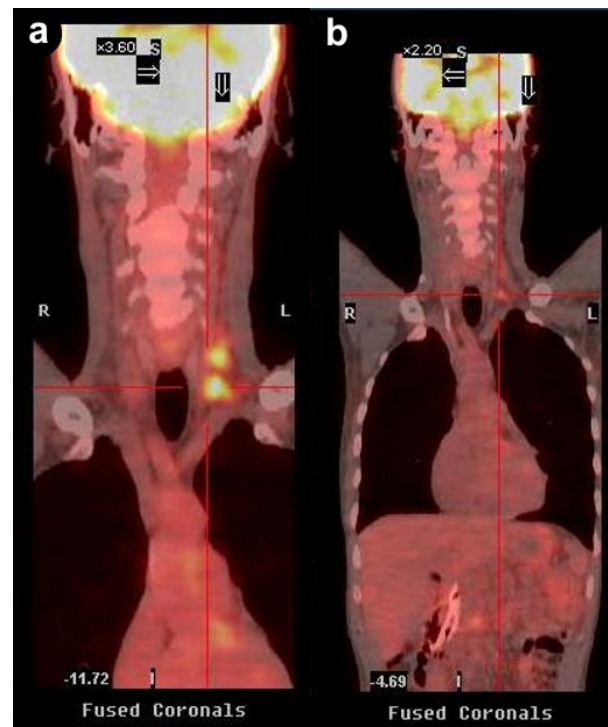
PET/CT scans of Patient #1 before (a.) and after (b.) chemotherapy showing supraclavicular metastasis. After 5 cycles of chemotherapy, PET/CT scan (b.) shows favorable response to therapy with decrease in SUV of supraclavicular lymph nodes from 4.3-4.7 (baseline, a.) to 2.4 (b.).
